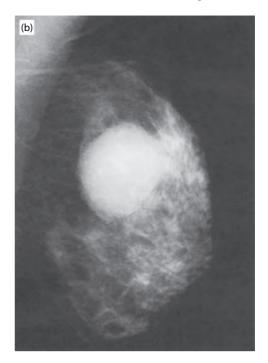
Cyst: radiological appearances using (a) ultrasound, showing an anechoic lesion with distal bright up; (b) mammogram of a breast cyst showing a large well-defined, oval mass.
